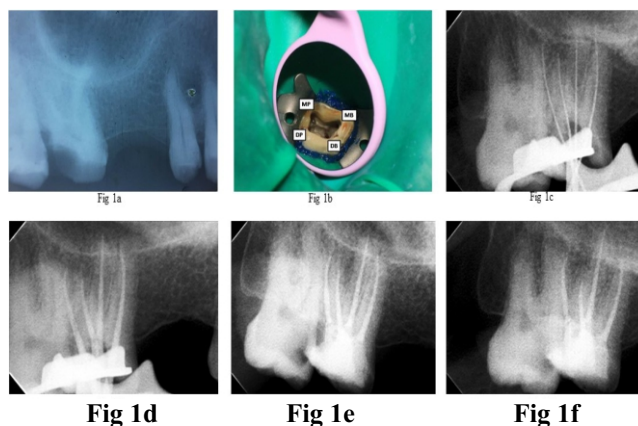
Pre-Operative Radiograph, Figure 1b : Access Opening showing four canal orifices (MP= Mesio-Palata, MB = Mesio-Buccal, DB = Disto-buccal, DP = Disto-Palatal), Figure 1c : Working Length Radiograph, Figure 1d : Master Cone Radiograph, Figure 1e : Post-Obturation Radiograph, Figure 1f : 1 Year Follow up
